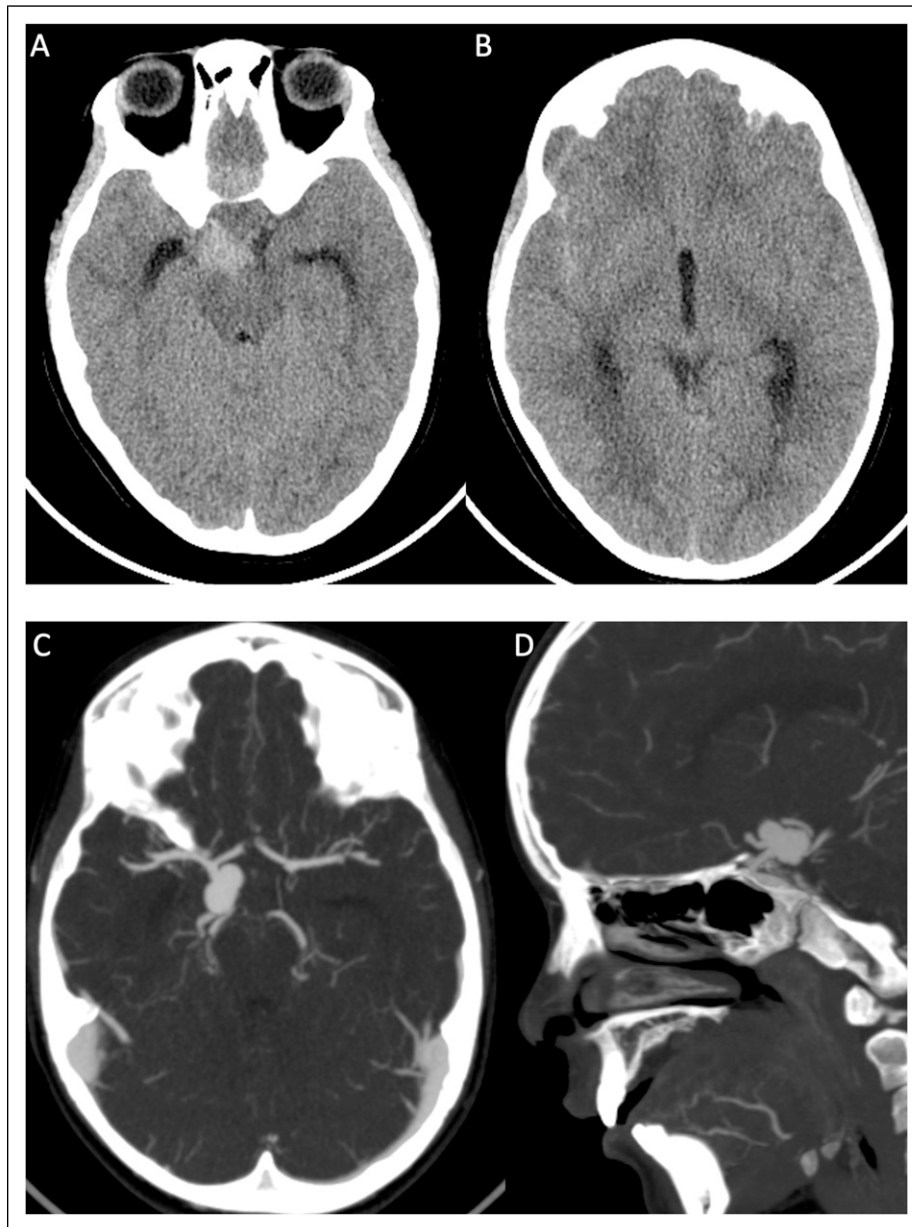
CT scan showing basal cisterns and right sylvian fissure subarachnoid hemorrhage. CT angiography showing the presence of ICA aneurysm located within the posterior communicating segment.
